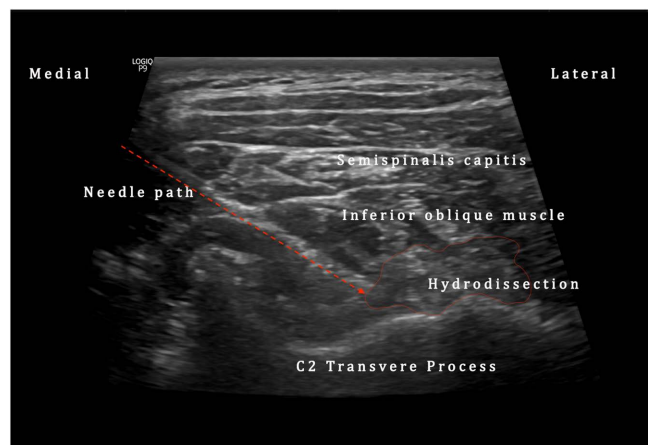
Labelled ultrasound image of occipital hydrodissection.
